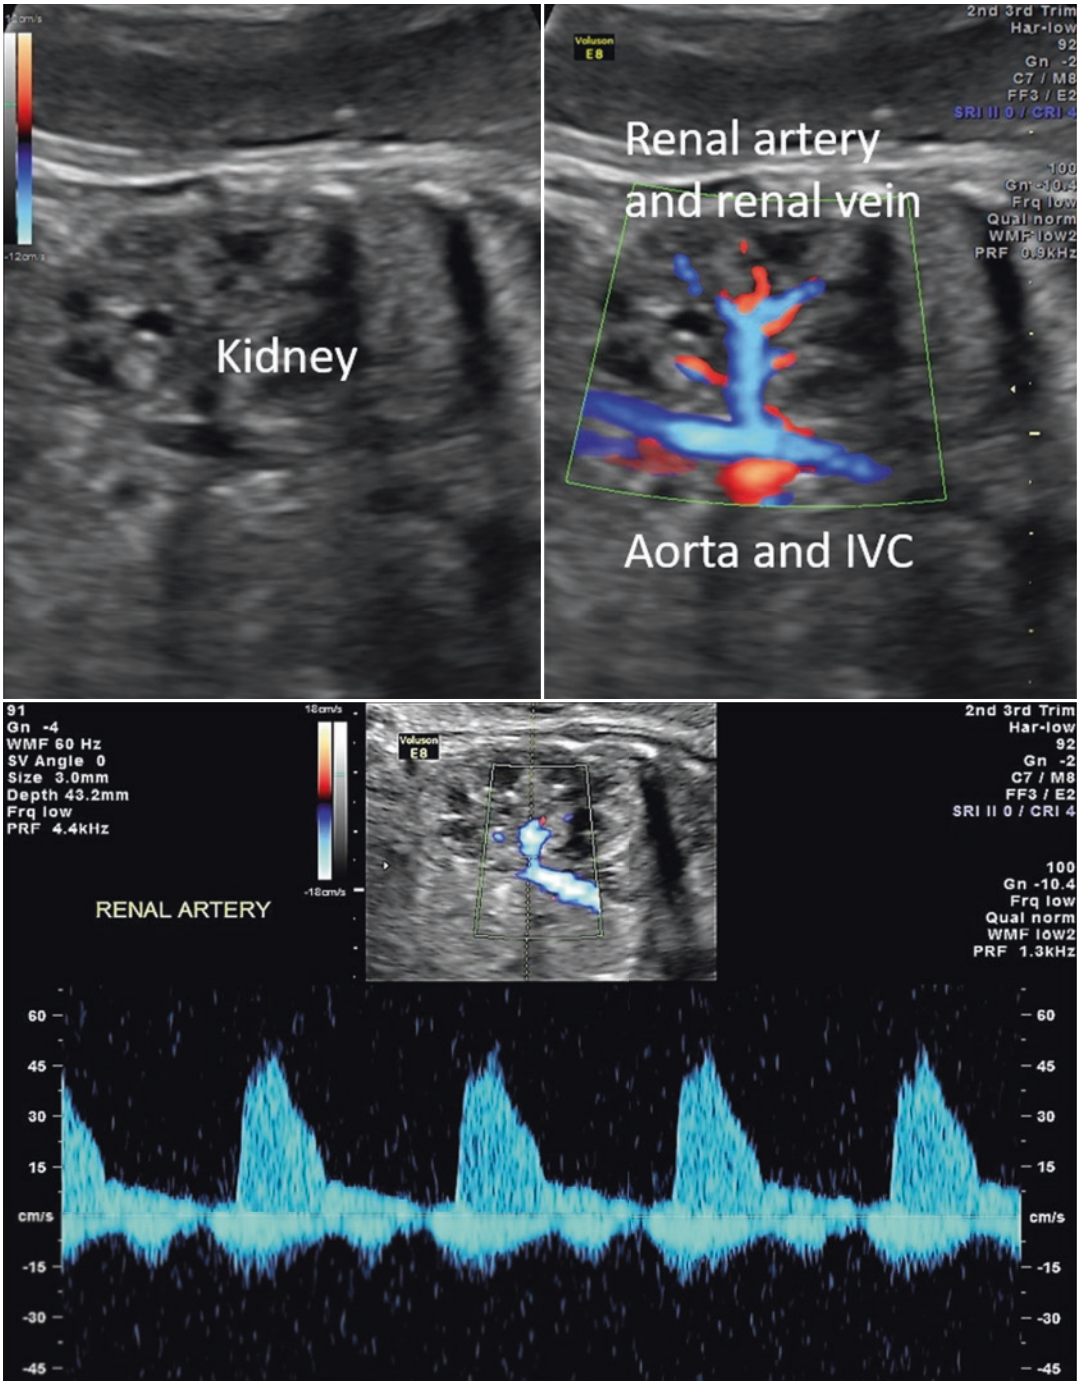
Grayscale (top left panel) and application of color Doppler (top right panel) on a coronal view of the fetal kidney and vascular pedicle. The lower panel demonstrates the high resistance waveform of the renal artery
